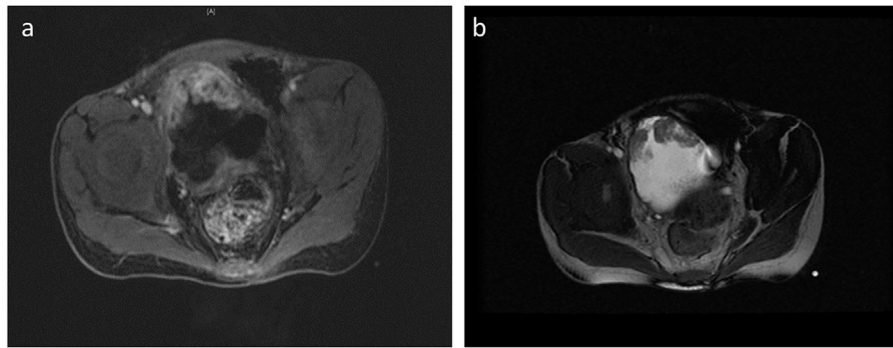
MRI images of bladder mass: a) T1 weighted b) T2 weighted.
